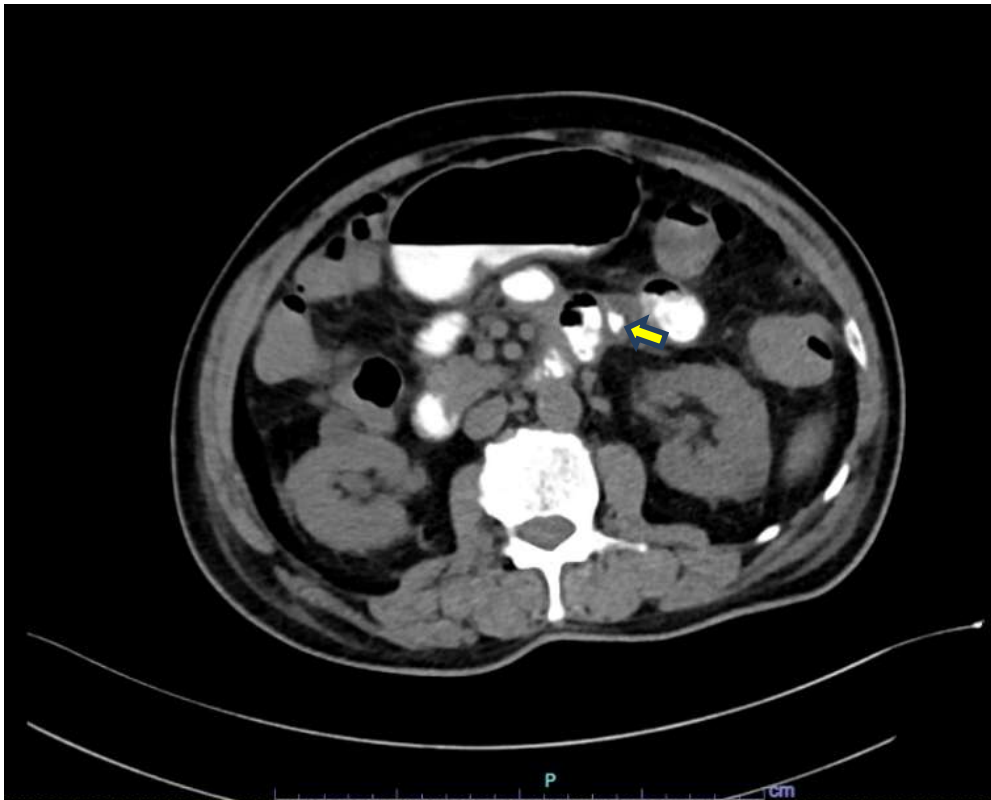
Contrast extravasation from jejunal diverticula seen on CT abdomen dated 28-04-2023.
